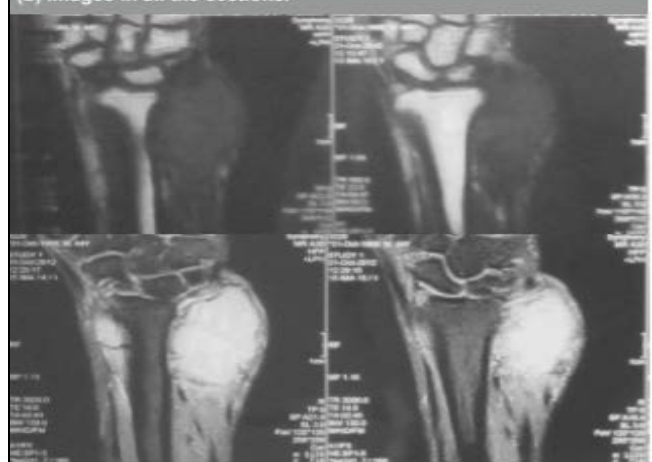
Magnetic resonance imaging of Lt. Forearm & wrist shows hypointense signal in T1W (a) and hyperintense signal in T2W (b) images in all the sections.
